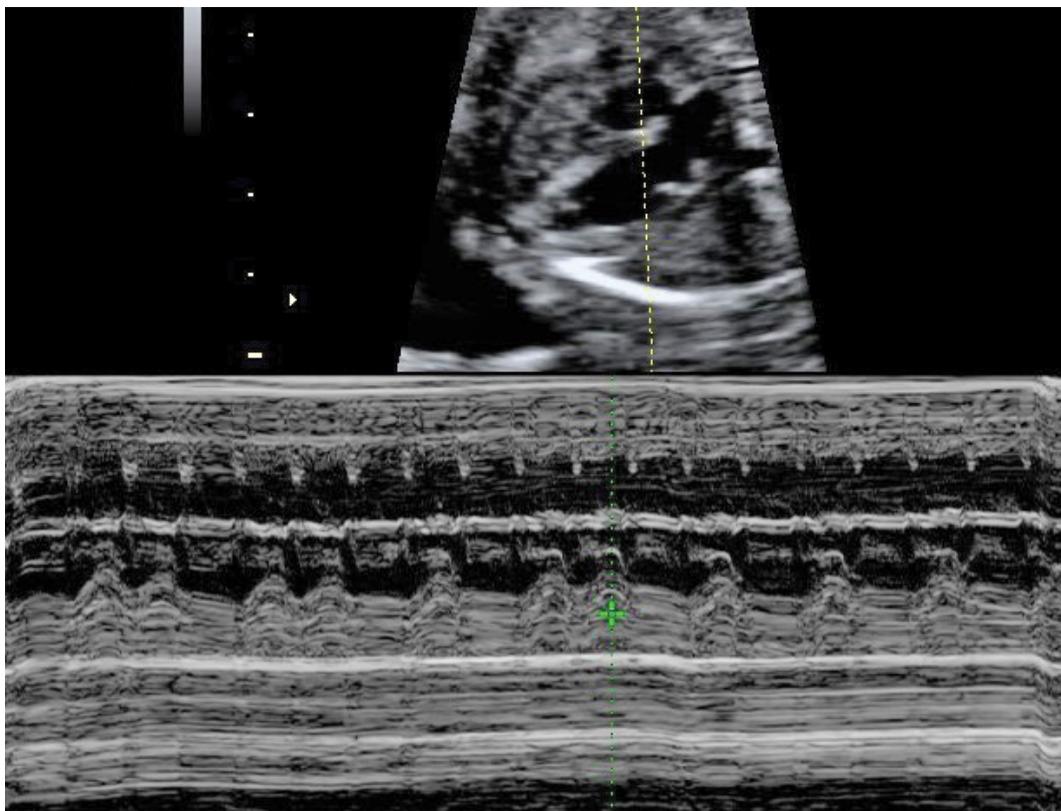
Fetal echocardiogram in a 24 weeks pregnancy. M-mode shows abnormal atrioventricular conduction with type 2 atrioventricular fetal block (personal collection Anca Maria Panaitescu)
